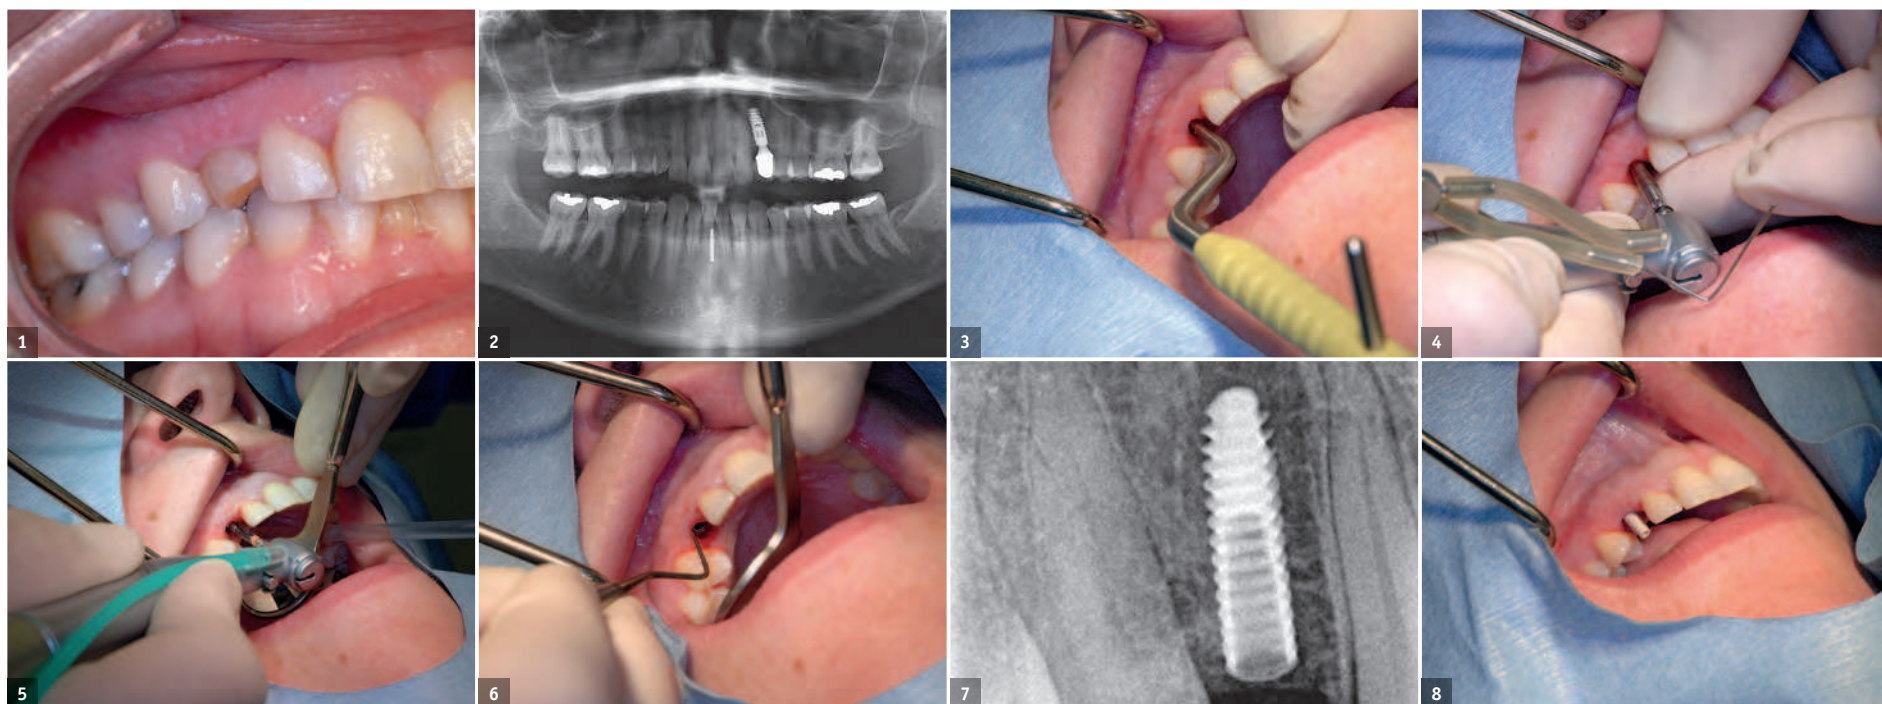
Initial situation with the strongly resorbed tooth #53 in situ.—Fig. 2: Dental panoramic tomogram showing the initial situation.—Fig. 3: The preparation was performed precisely using a Nentwig osteotome.—Fig. 4: The autologous bone was ground and harvested using the K-system.—Fig. 5: The preparation was performed to the correct depth using a 2.6 drill.—Fig. 6: Insertion of the implant 1 mm below the bone crest level.—Fig. 7: Radiograph after implantation.—Fig. 8: The PEEK abutment in situ.
